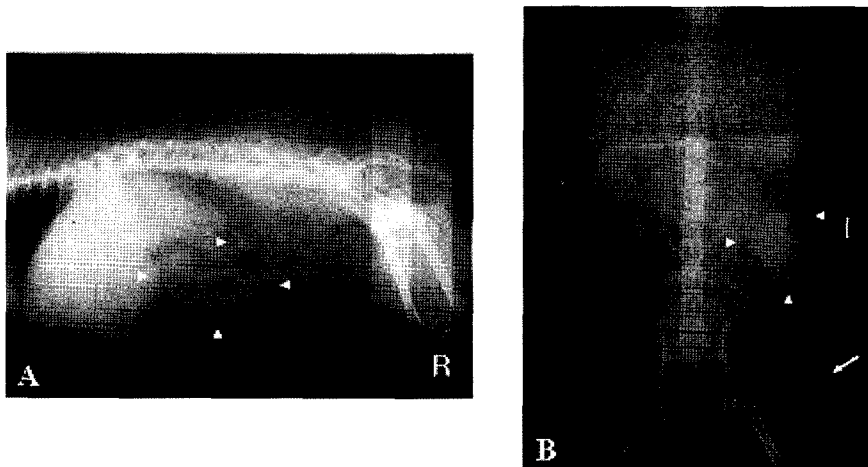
Survey radiography of retained surgical gauze in case 2. Lateral (A) and ventrodorsal (B) radiographs in which a localized and irregular mass with soft tissue opacity was visible in the left abdomen. Swelling of the left rump was shown (arrow).
